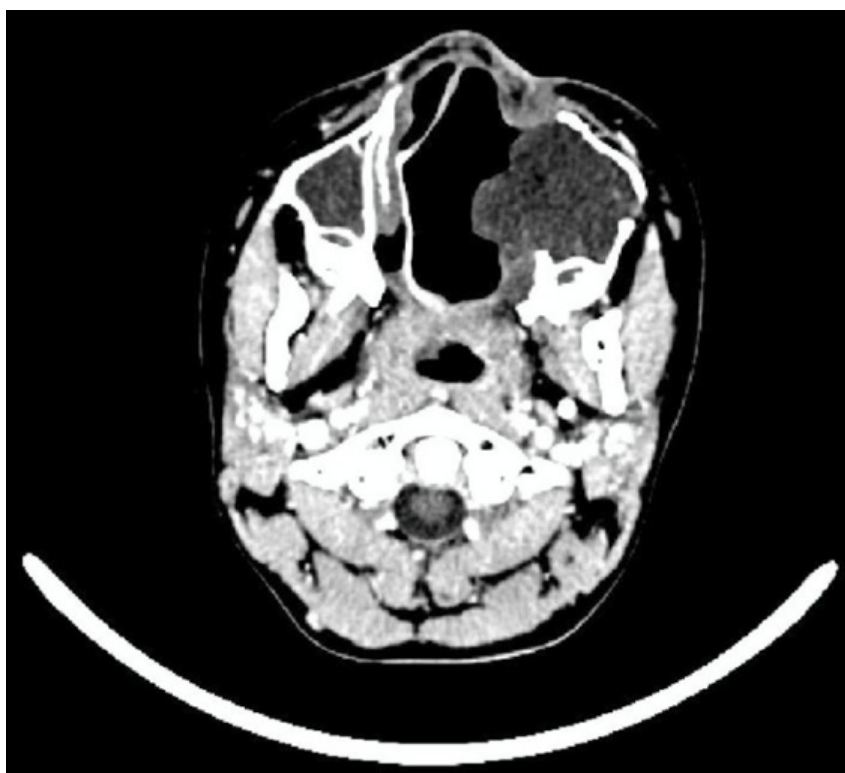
CT scan revealed isodens lesion with extension to nasal cavity and left maxillary sinus
